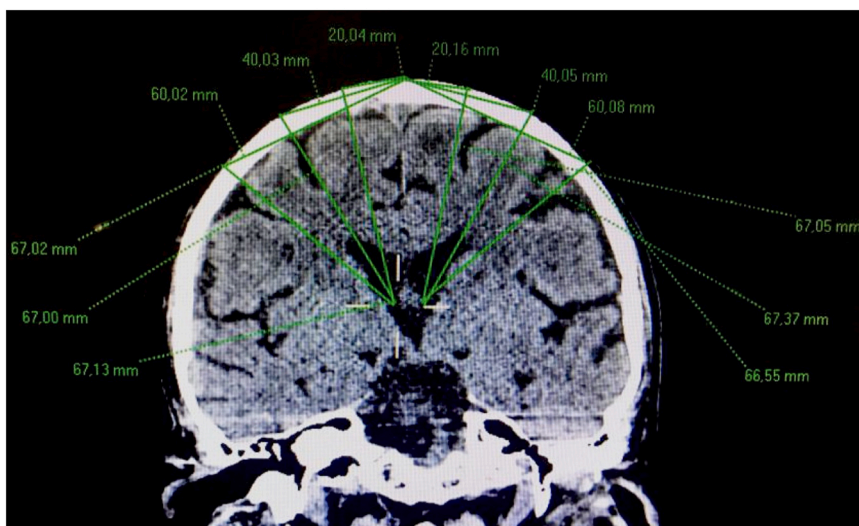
CT scan showing the result of the second part radiological study. Coronal CT image showing the distance (mm) from the midline to six entry points on frontal bone and the distance (mm) from the outer cranial table to the foramen of Monro.
